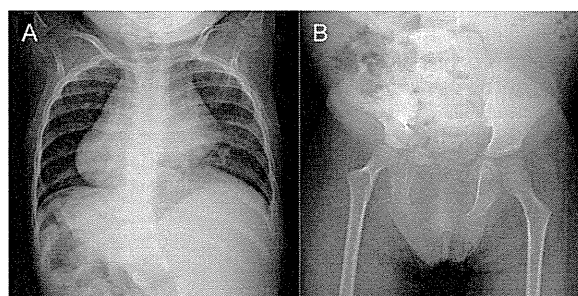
Skeletal characteristics of the proposita. Anteroposterior radiographs of the chest (A), pelvis and the lower extremities (B) at 2 years and 6 months of age show vertical iliac wings and a right dislocated hip. Neither bent long bones nor scapular hypoplasia was present.
